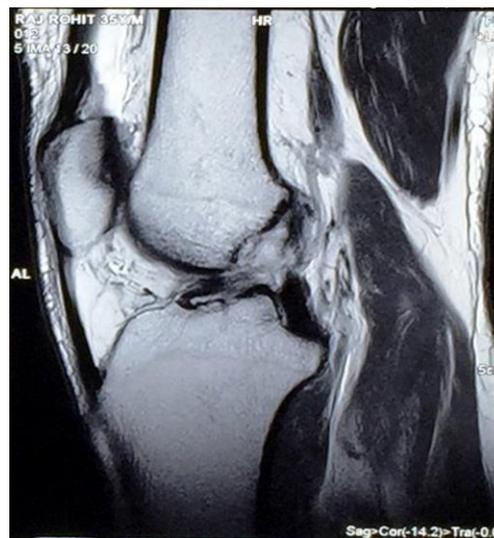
MRI in sagittal section showing mid substance tear of ACL. Note the increase in signal (hyperintense) within the course of ACL
